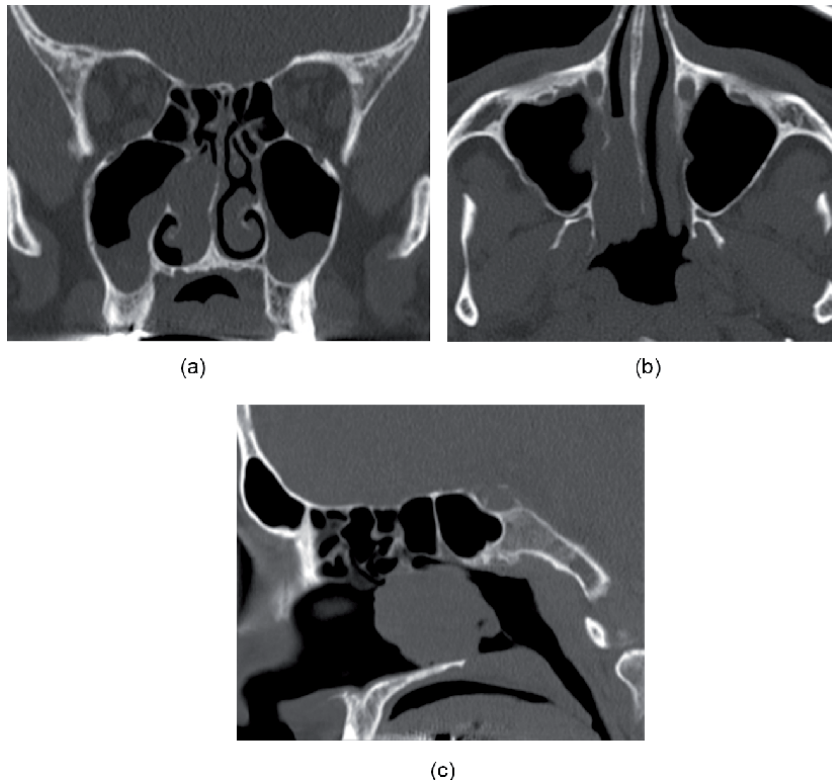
(a) Coronal, (b) axial, and (c) sagittal CT of an inverted papilloma originating from the ethmoid sinus and filling the middle part of the nasal cavity and choana. The site of origin often shows hyperkeratosis. In this case the origin could be from beneath the ethmoid cells that shows slight keratosis at the sagittal CT.
